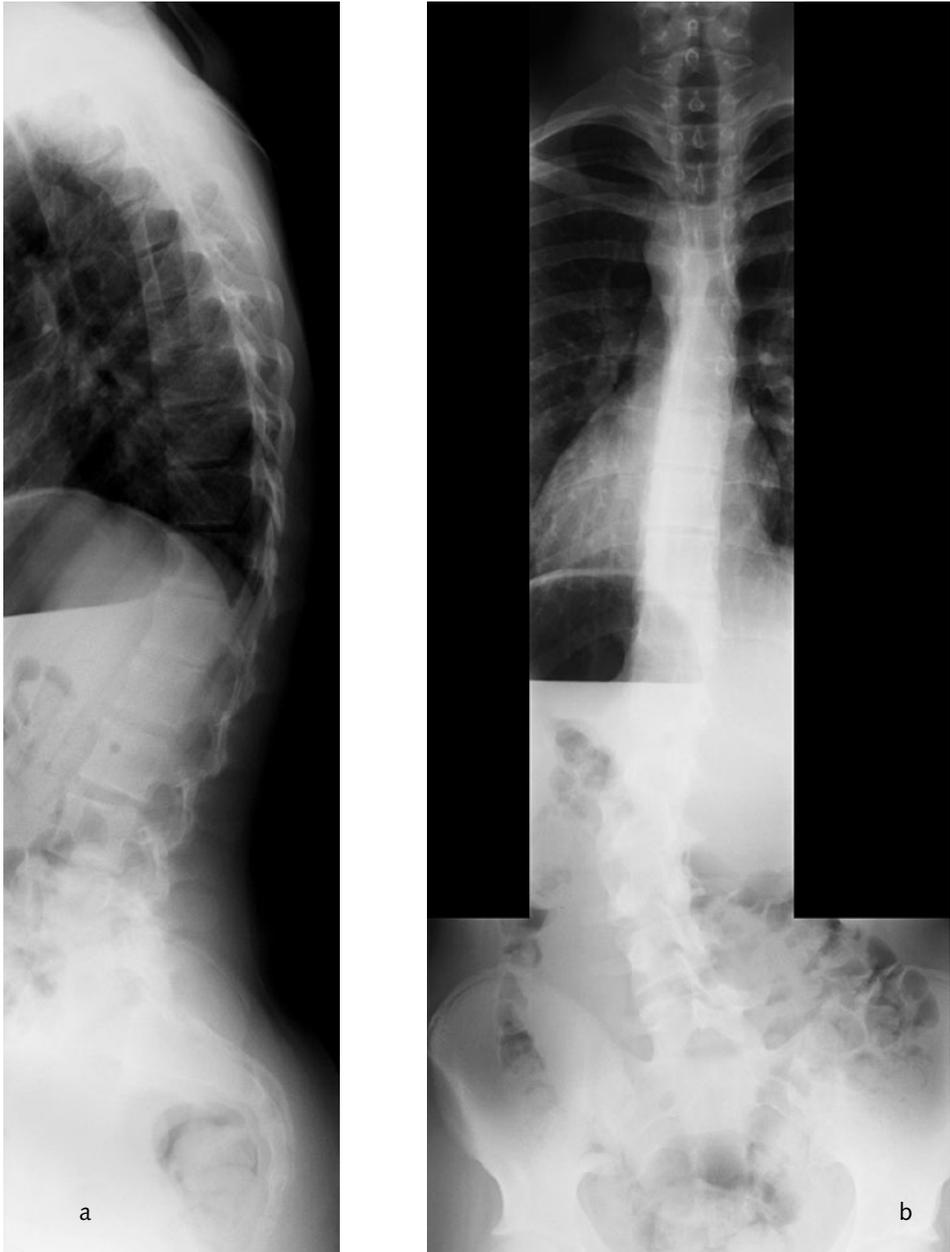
Lateral and AP X-ray of a Scheuermann's kyphosis. A shorter, but more backwardly declined segment of the spine (a) is subject to a greater dorsal shear force over fewer vertebrae. This corresponds to the rotated segment in the frontal plane (b). Data compiled from Castelein *et al.*²⁷
